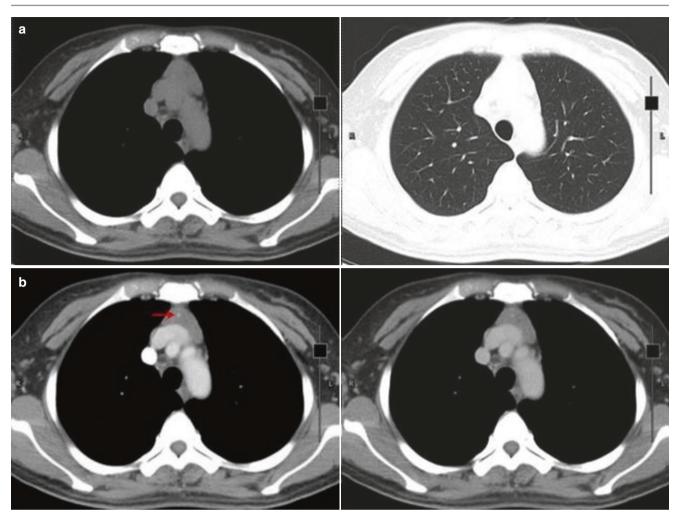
Chest CT image in a 41-year-old woman showed a triangular or arrowhead-shaped thymus at the level of the aortic arch. Contrastenhanced CT scan showed slightly enhanced and vascular shadow (red arrow)
